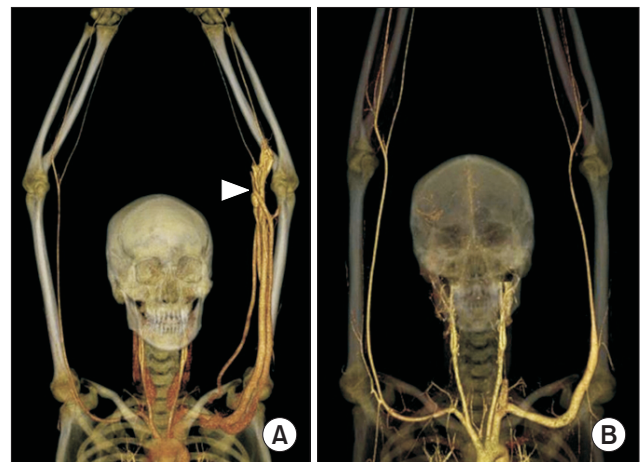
Preoperative CT angiogram. (A) A brachial arteriovenous fistula (white arrowhead) with an engorged vein. (B) Postoperative 6-month CT angiogram showed a normalized artery. CT, computed tomography.
